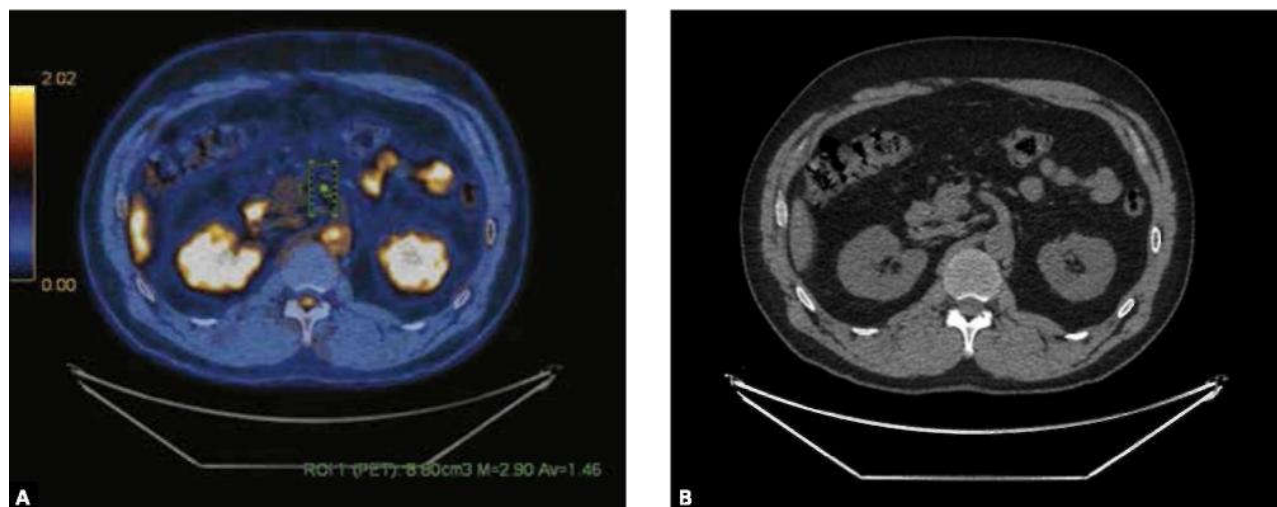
Badanie 18F-FDG PET/CT-w projekcjach poprzecznej i strzałkowych widoczna poszerzona tętnica kręzkowa górna do 11 mm z rozlanym, miernie wzmożonym metabolizmem 18F-FDG,  $SUV_{max}$  2,3
